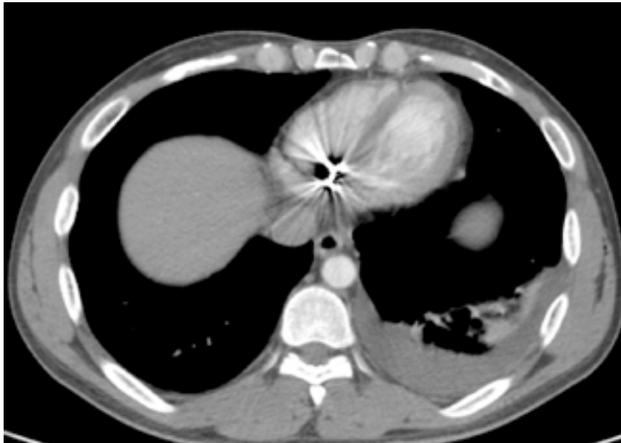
Axial CT scan showing a single pellet in the interventricular septum, with no suggestion of cardiac or mediastinal injury.
